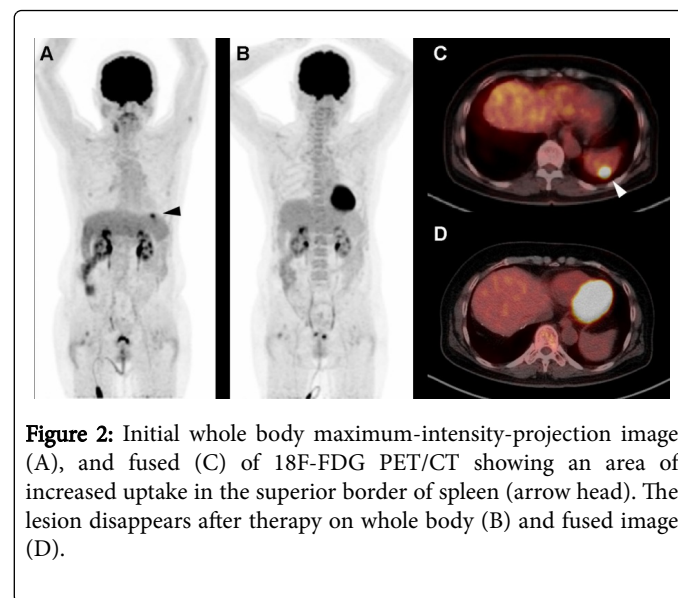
Initial whole body maximum-intensity-projection image (A), and fused (C) of 18F-FDG PET/CT showing an area of increased uptake in the superior border of spleen (arrow head). The lesion disappears after therapy on whole body (B) and fused image (D).
